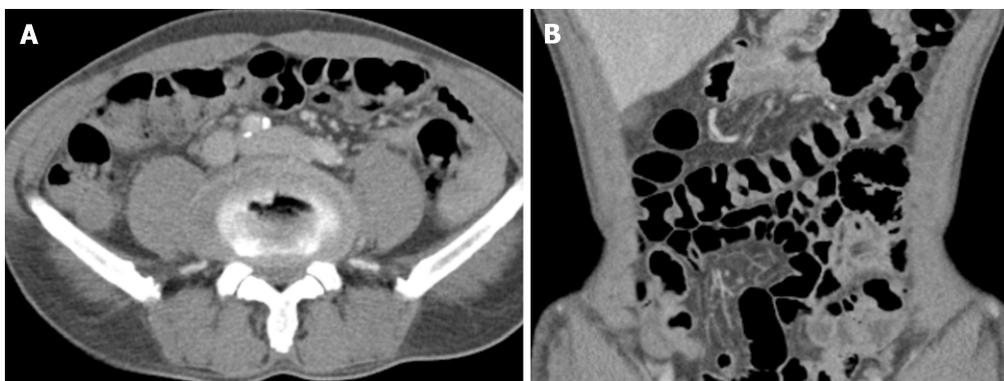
Post treatment abdominopelvic computed tomography. A and B: After removal state of parasite, repeated computed tomography images demonstrate the disappearance of colo-colonic intussusception.
